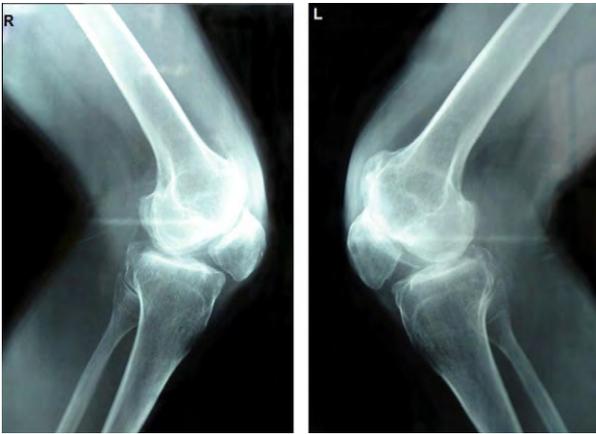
The typical X-ray of patella Baja.
